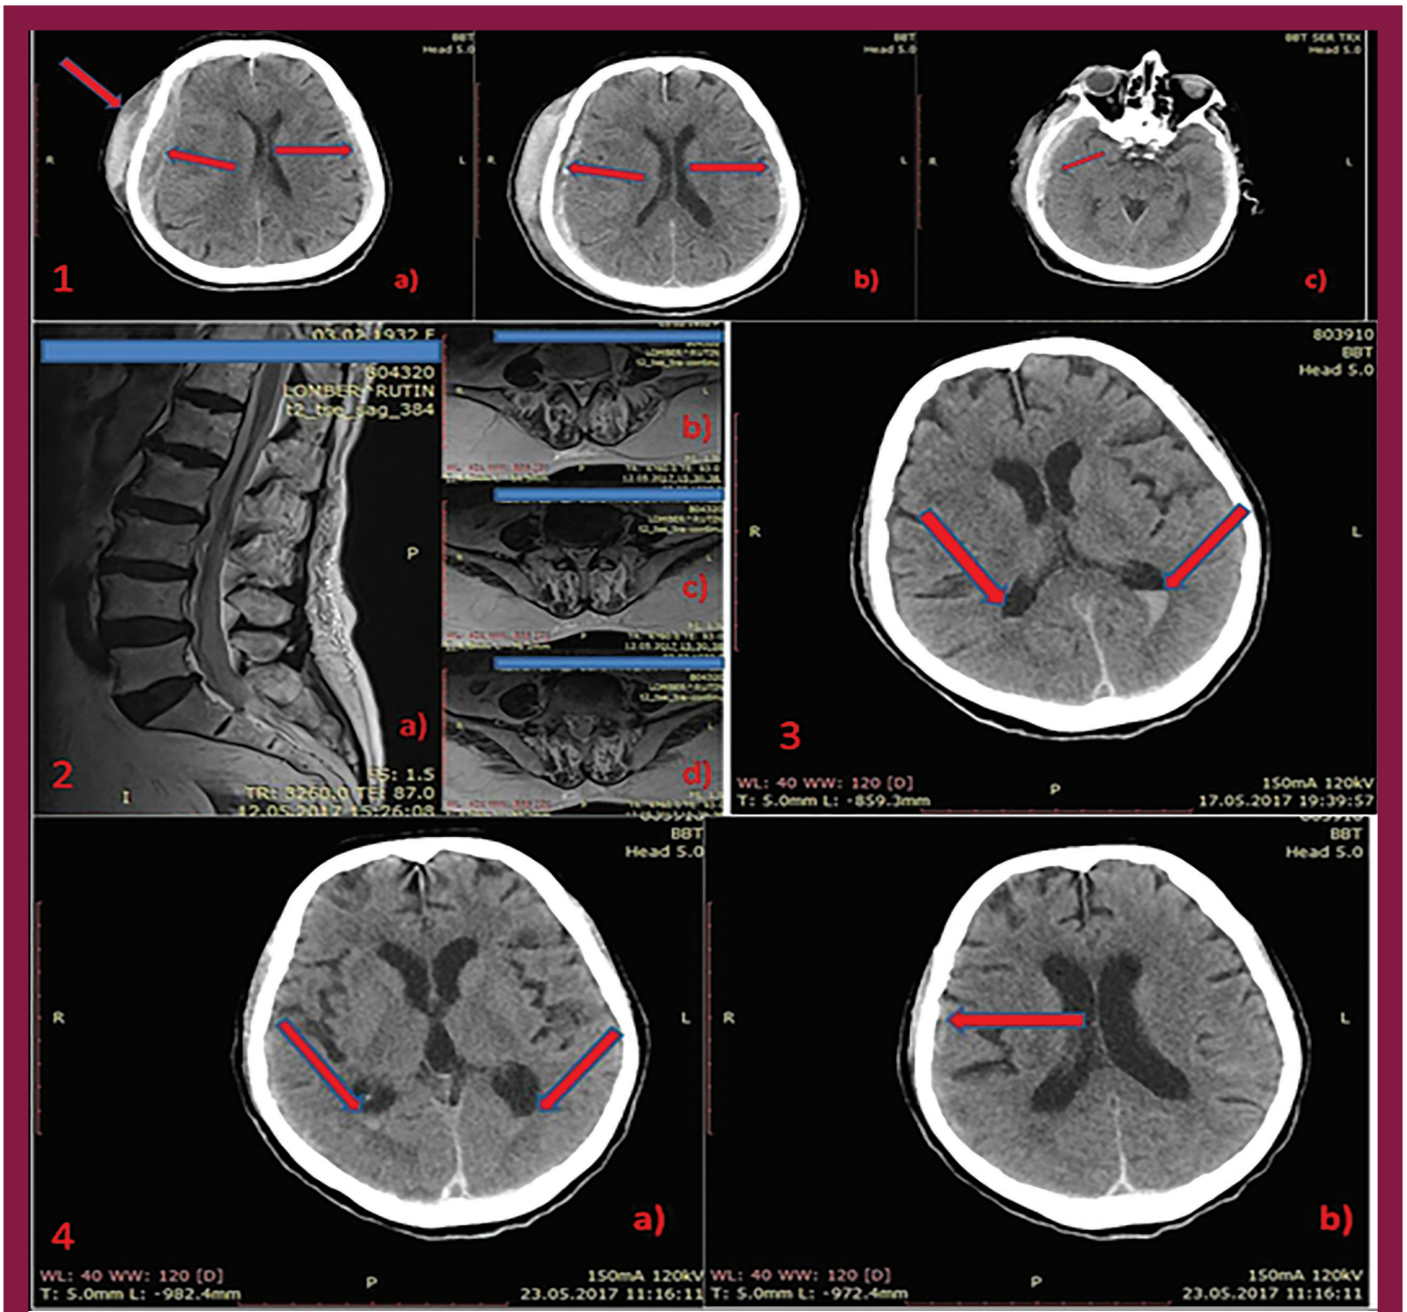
Cranial CT was initially performed and demonstrated bilateral frontoparietal TASH with a midline shift and cephal hematoma. (red arrows)
